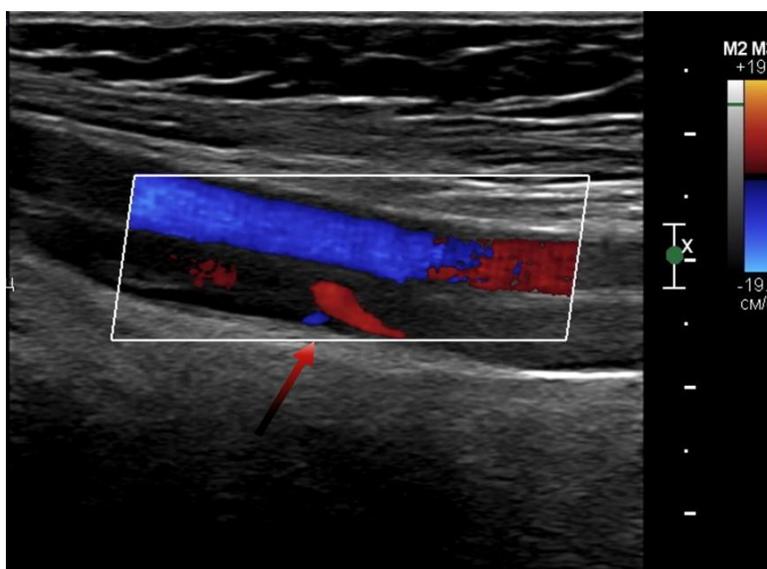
Ultrasonography of the lower extremity
